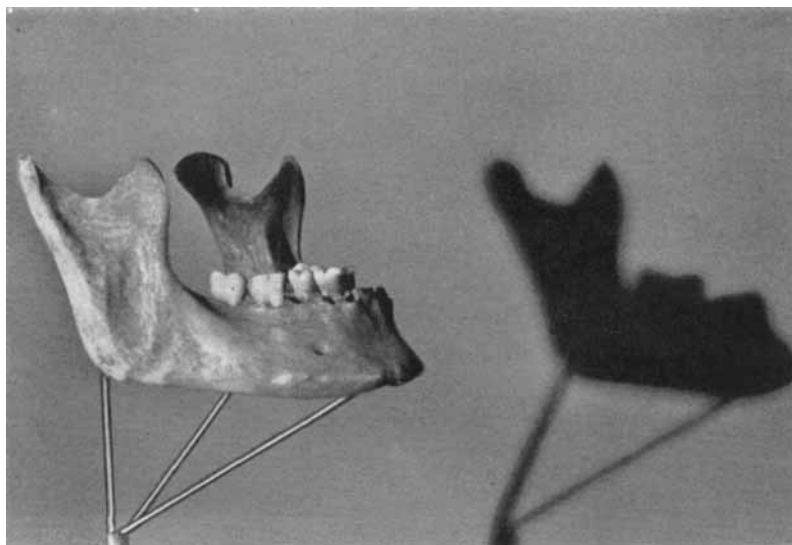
Mandible on rotatable frame for checking of tracing of profile roentgenograms. The entire apparatus is shown in Fig. 2.
